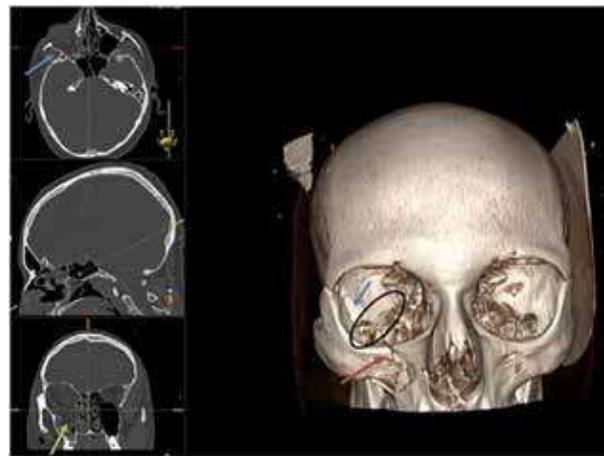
MRI brain with bone window & 3D Facial bones (AP view) showing zygomatic maxilla fracture with inferior Orbit fracture
